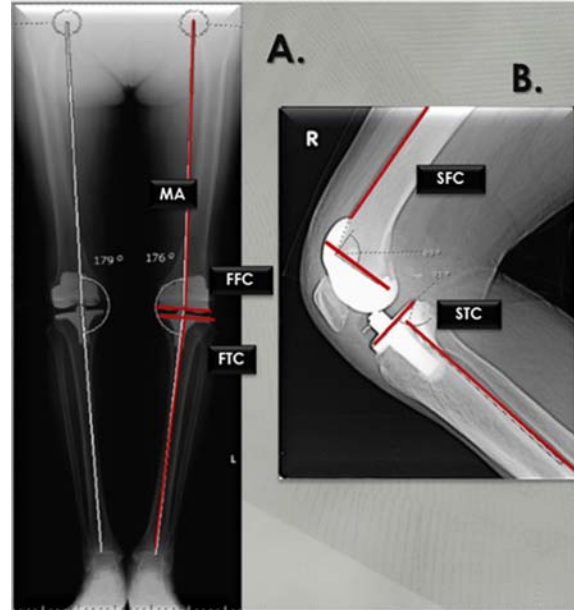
Digital long-leg weight-bearing radiographs. The line of mechanical axis (MA), femoral component in coronal plane (FFC) and Tibial component in coronal plane (FTC) were measured in anteroposterior films (A.), the femoral component in sagittal plane(SFC) and tibial component in sagittal plane (STC) were measured in 90° flexion lateral films
